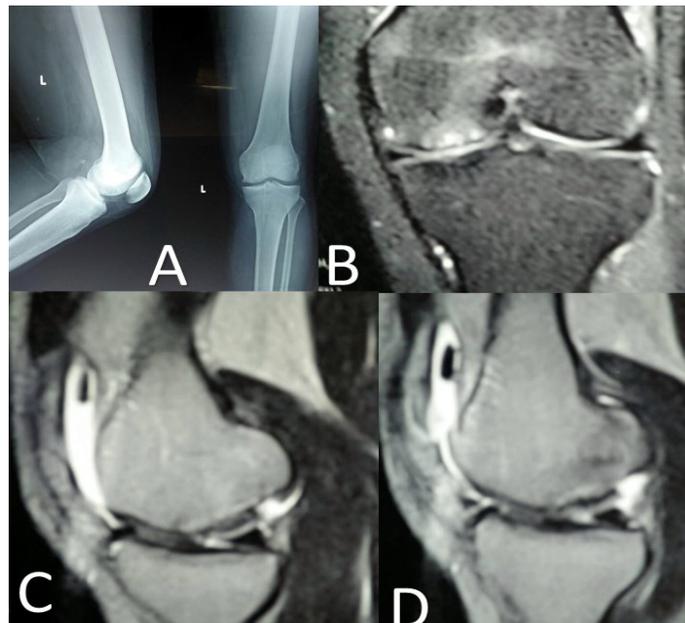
A) plain x-ray preoperative; B.C.D) (coronal – sagittal view. MRI showing osteochondral defect on M.F.C
